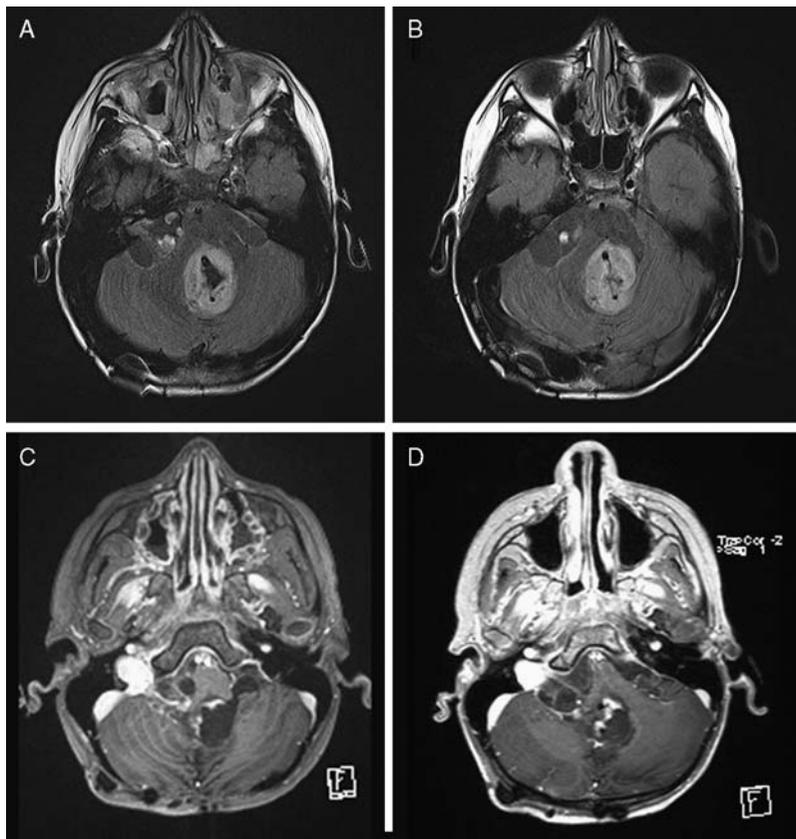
Neuroimaging of the patient’s primary pilocytic astrocytoma at baseline and after 8 weeks on sorafenib. Magnetic resonance imaging axial views of (A) fluid-attenuated inversion recovery (FLAIR) and (C) T1-weighted postcontrast selected images obtained before initiating treatment showing the disseminated enhancing tumor in the fourth ventricle and within the dorsal midbrain, associated with an encysted fluid collection in the right cerebellopontine angle into the right internal auditory canal. Similar (B) FLAIR and (D) T1-weighted postcontrast axial planes after 2 cycles of treatment with sorafenib showing interval increase in the size of the area of abnormal FLAIR hyperintensity with further effacement of the fourth ventricle and thickening of the nodular contrast enhancement, consistent with tumor progression.
